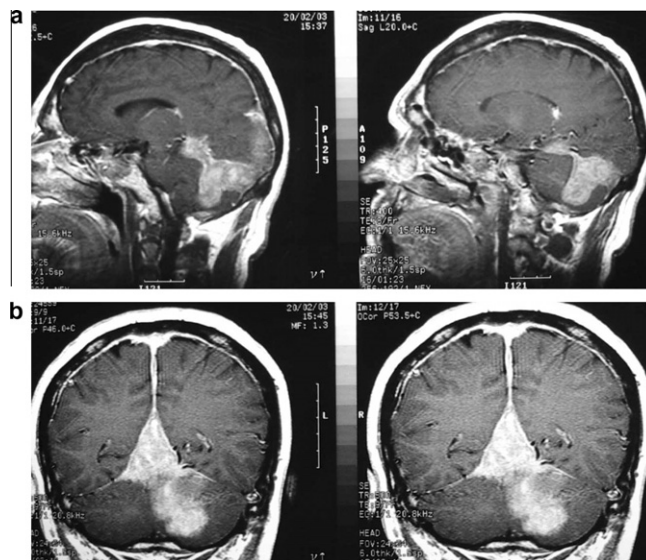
(a) Sagittal and (b) coronal T1-weighted postcontrast brain MRI showing a homogeneous infra- and supra-tentorial tumor with a dural tail sign at the level of the torcular with encasement of the posterior aspect of the superior sagittal sinus, the straight sinus and transverse sinuses.
